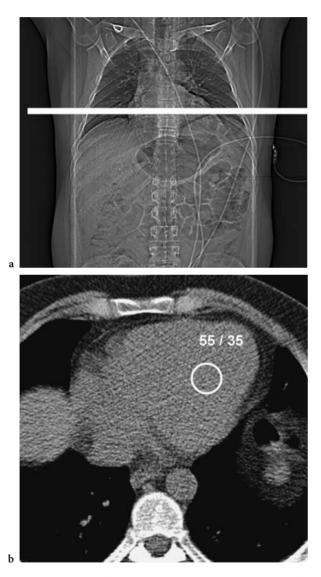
a Using the topogram, a slice is positioned on the basis of the heart. b Slice is acquired at the level defined in a, the noise is measured in the left ventricle as the standard deviation of the value of the pixels within the region of interest (*circle*). Here the standard deviation was found to be 35 HU, leading to set radiation dose parameters at 120 kV and 900 mAS (see Table 12.1) for the subsequent contrastenhanced coronary CT
